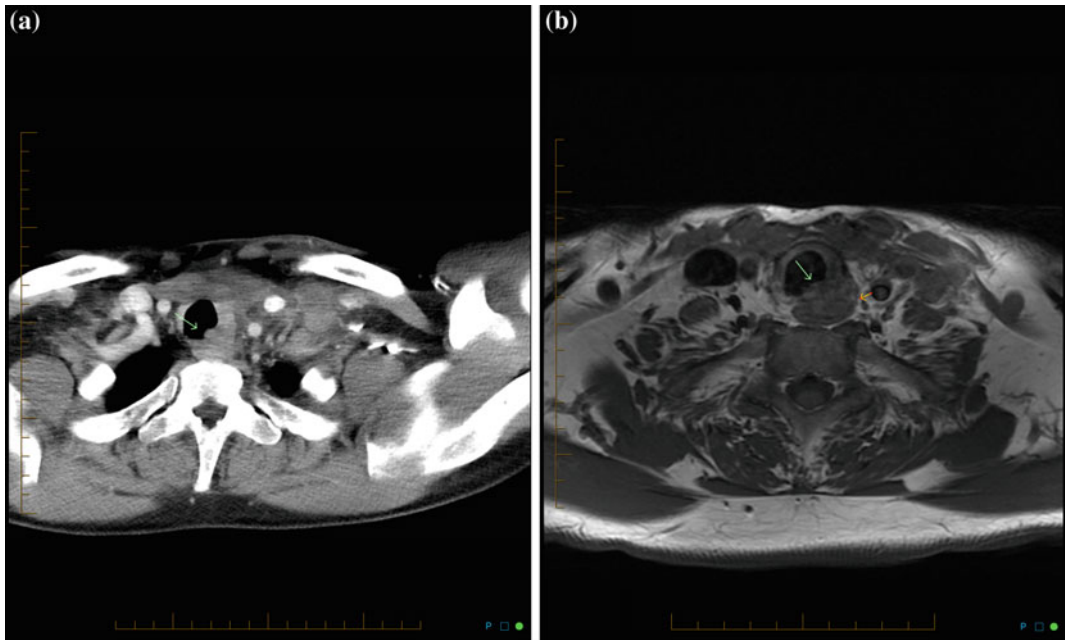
a Axial CT scan demonstrating recurrent MTC invading esophagus and trachea. b T1 Axial MRI
